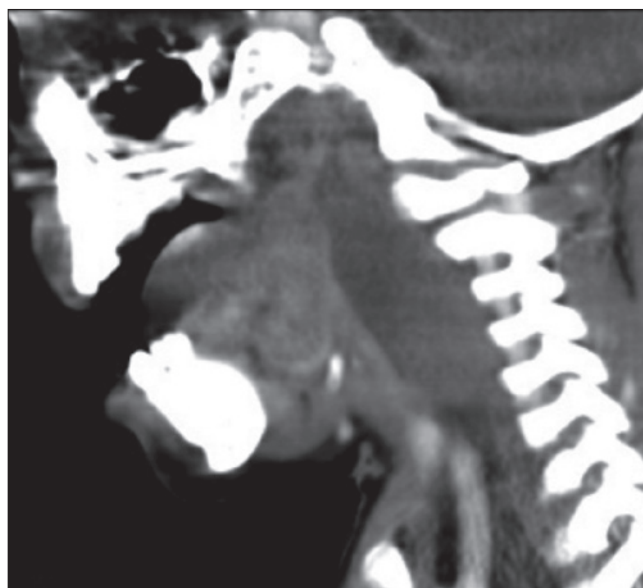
Contrast sagittal CT scan showing retropharyngeal lymphatic malformation from the nasopharynx to the level of C6.
